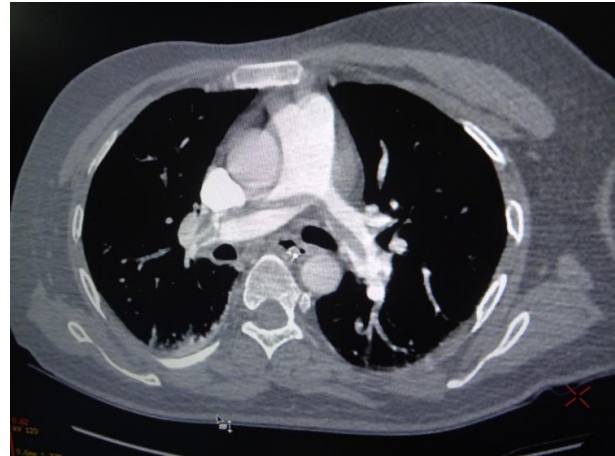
CT showing thrombus in both pulmonary artery extending from bifurcation
